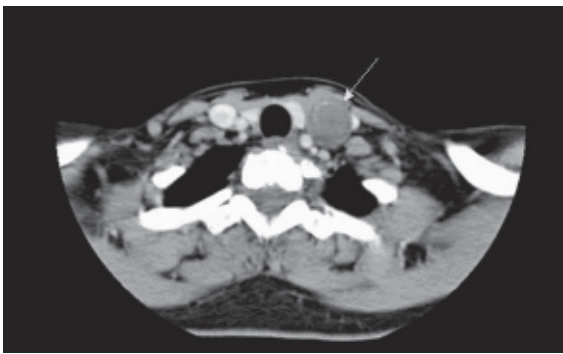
CT of patient GMP showing a solitary well-circumscribed vagal schwannoma (arrow) measuring approximately 2.6 x 2.3 cm in the left side of the root of the neck just lateral to the left thyroid lobe. The schwannoma shows homogenous soft tissue attenuation (30 HU) and its unique location with resulting splaying of the left common carotid artery from the internal jugular vein is noted.
